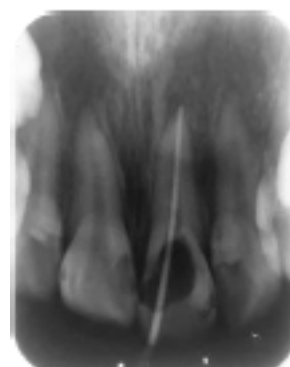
Master apical cone radiograph checking. Radiograph showed good adaptation between master cone and apical constriction.
